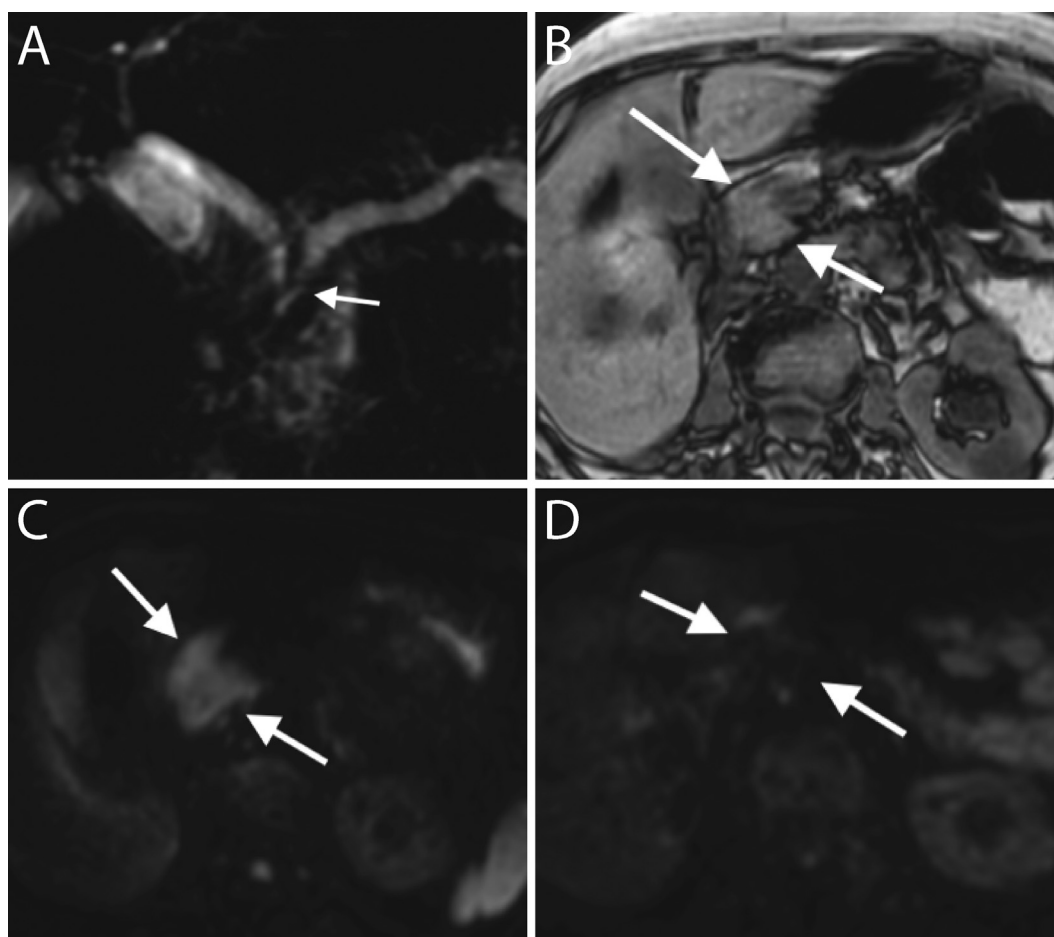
(A) Magnetic resonance cholangiopancreatography showing main pancreatic duct dilatation (calibre, 5 mm), secondary to a tapered stricture (white arrow) in the pancreatic head. (B) On T1-weighted morphologic image, pancreatic head (arrows) has normal signal intensity with no evidence of solid focal lesions. (C) On diffusion-weighted image, a marked increase in signal intensity of the same region of the pancreatic head (arrows), indicating restricted diffusion, is evident. (D) At imaging follow-up, using diffusion-weighted images, complete normalisation of signal intensity of the pancreatic head is observed.
